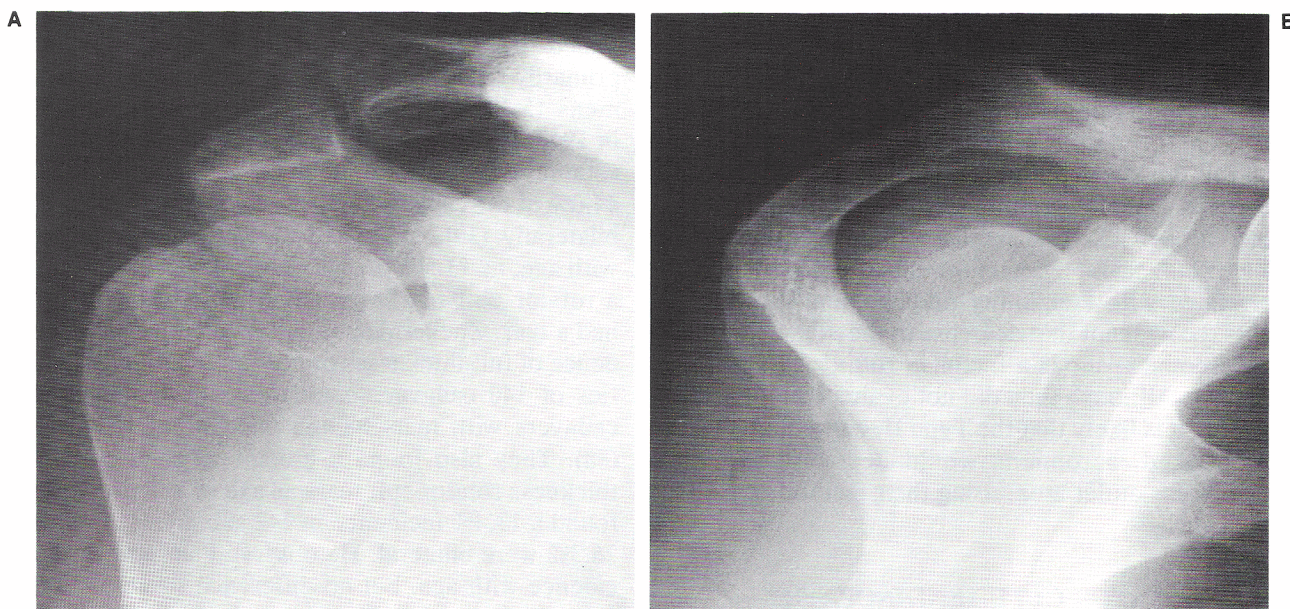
A: Anteroposterior radiograph of the scapula from a 29-year-old male patient demonstrating the bone-to-bone interval between the acromion and humerus. B: Supraspinatus outlet radiograph of the same individual, with the Type II acromion, again demonstrating the interval between the acromion and humerus.
